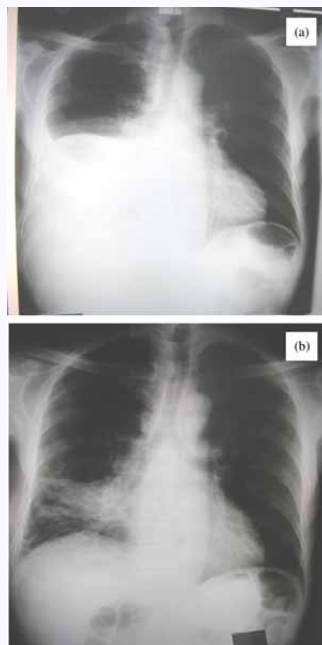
Chest X-rays done during the first hospital admission: (a) before and (b) after thoracocentesis. After drainage of the right-sided pleural effusion, there was a heterogenous opacity over the right lower lung field.
